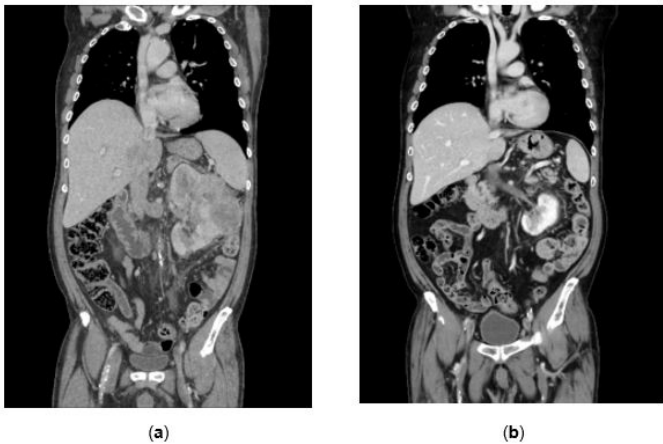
Case 1 Coronal CT scan before; (a) and after (b) ICIs/TKI combination treatment.
